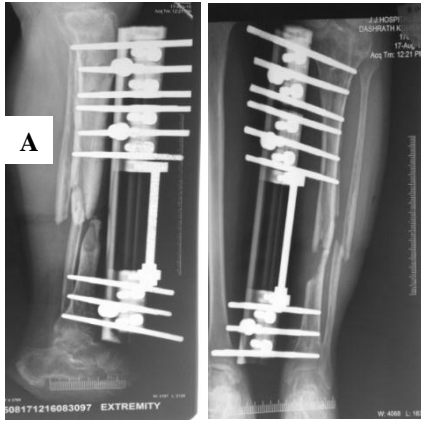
Immediate post-operative X-ray showing diaphyseal tibia fracture with bone loss treated with LRS.
